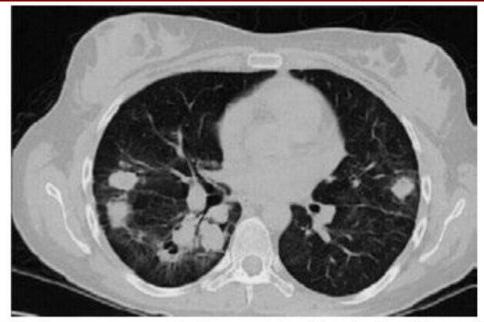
1 Bilateral nodular infiltrates seen on computed tomography of the chest in a 40-year-old woman with granulomatosis with polyangiitis (Wegener's).
